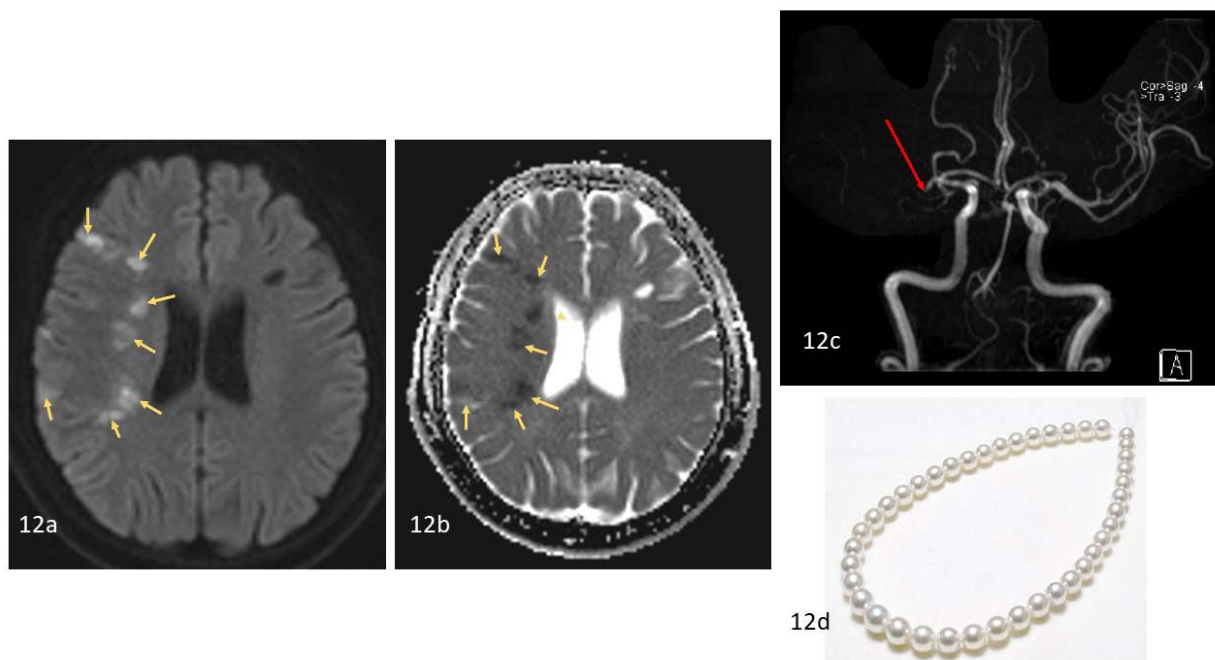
Strings of pearls sign. 48 year old female with acute watershed infarcts in the right MCA territory. Multiple foci of restricted diffusion, appearing bright on DWI (12a) and dark on ADC (12b) are seen in the right frontal and right temporal lobes as well as in the right corona radiata (yellow arrows) in the internal and cortical border zones between the right MCA and right ACA and PCA, resembling a string of pearls. This is suggestive of acute watershed infarcts in the right MCA territory. (12c) Time of Flight MR angiography of the Circle of Willis 3D volume-rendered reconstruction shows abrupt cut-off at the proximal right M1 segment (red arrow), likely due to an occlusive thrombus. Siemens Aera, 1.5 Tesla, Slice width 5.0 mm, TR 5040, TE 52, FA 180. (12d) String of pearls imagery.
